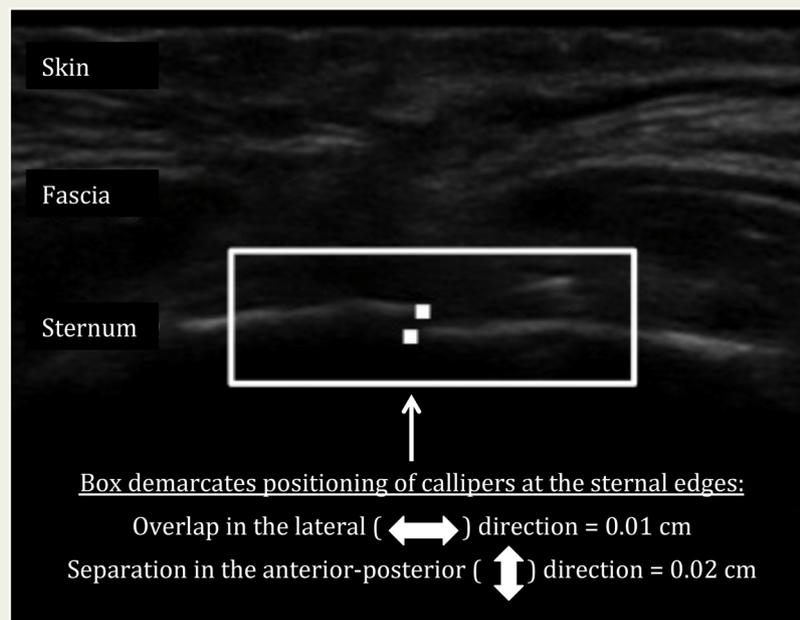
Sample ultrasound image of the sternum captured at rest depicting the overlap in the lateral direction and separation in the anterior-posterior direction of the sternal edges (cm).
